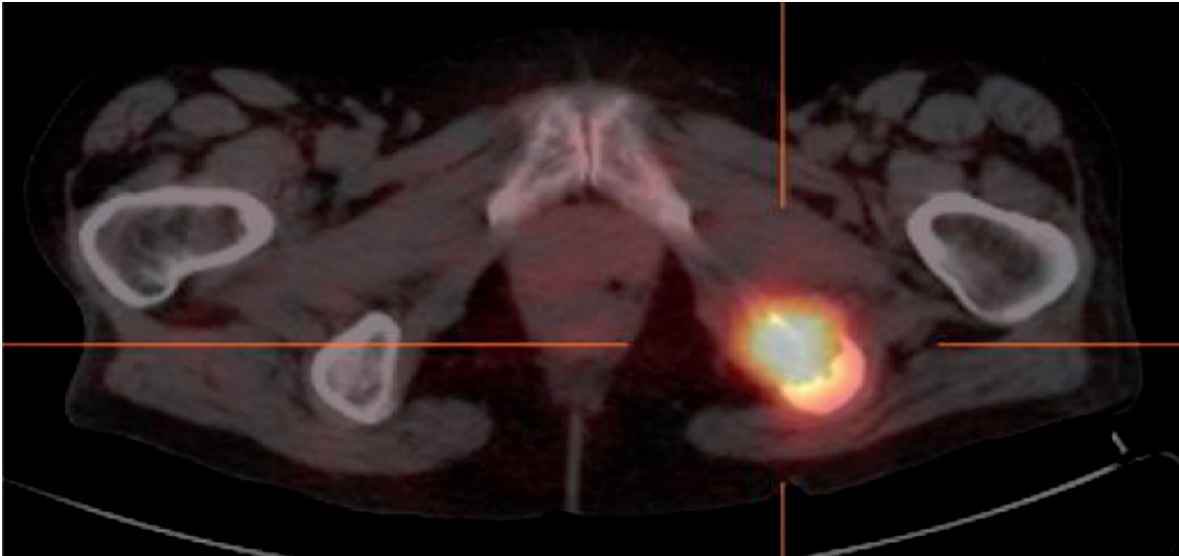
A  $^{111}\text{In}$ -octreotide SPECT/CT in Case 3 patient, as baseline before sunitinib treatment. The patient have a focus of markedly increased receptor density in the left tuber ischiadicum, showing relaps of disease after eight years remission.
